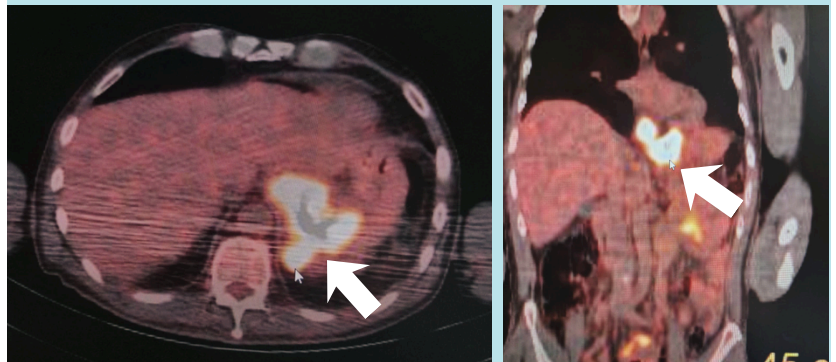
PET/CT demonstrating the tumorous lesion
